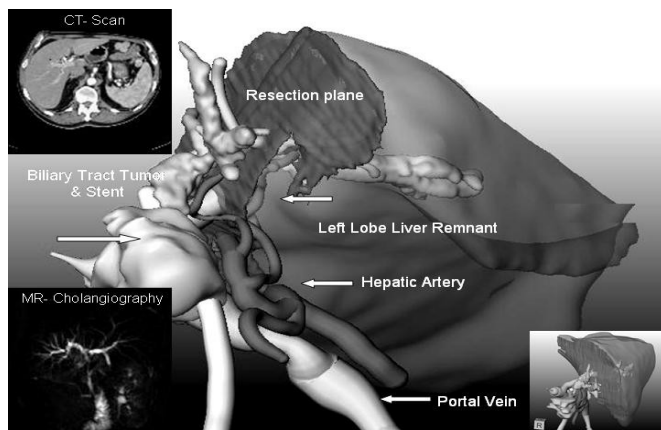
Computerized 3D visualization of a hilar biliary duct tumor, adjacent vascular structures the virtual oncological resection plane. Corresponding CT- scan and MR- cholangiography.
